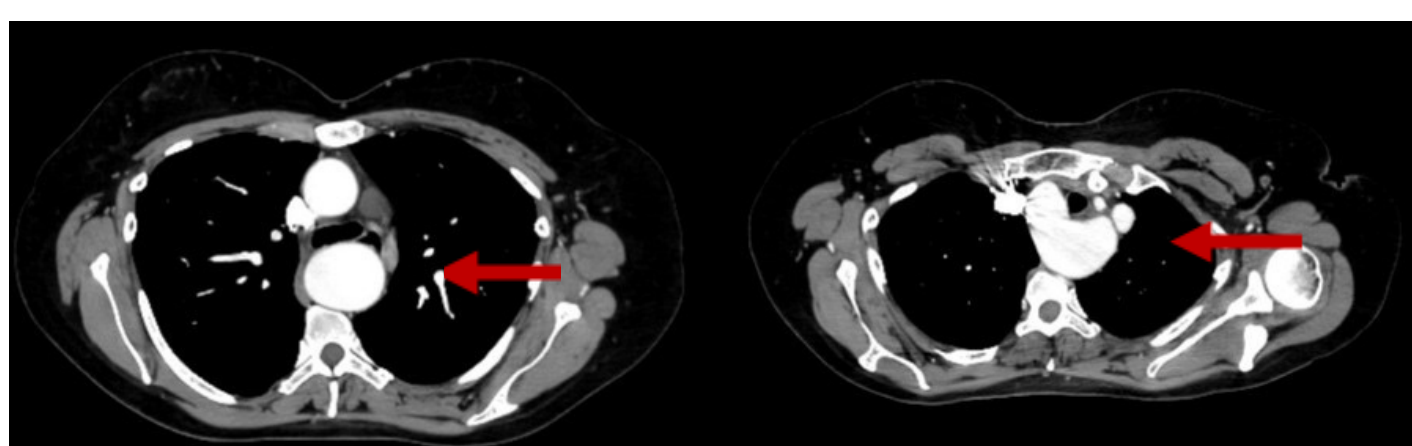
CT Angiogram showing aortic aneurysm of 45 mm
